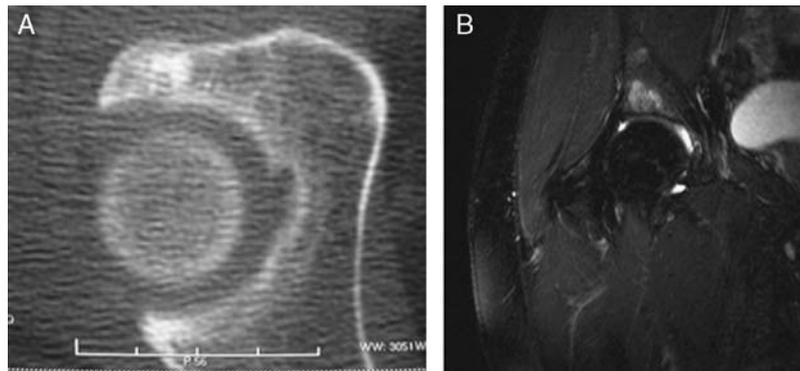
Patient 4. (A) CT showing lesion in the anterior wall of the acetabulum consistent with osteoid osteoma: sclerotic lesion (hyperdense) with a central nidus (hypodense). (B) T2-weighted MRI coronal slice showing an image of diffuse increased signal in the acetabular wall suggestive of the lesion.
